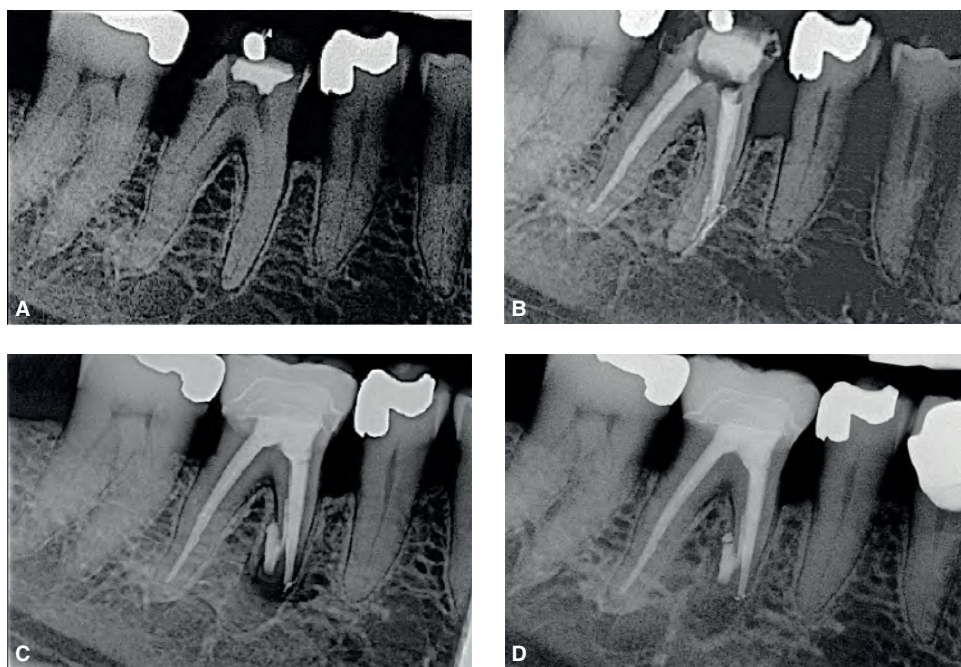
Calcification may complicate root canal treatment. A. Radiograph showing calcific metamorphosis in the coronal third of the root of the mandibular right first molar. The tooth is symptomatic to percussion. B. The clinician was not able to negotiate the mesial canals curvatures and perforated the distal side of the mesial root. The tooth is still symptomatic. C. Apical surgery was attempted to treat the defect. The retrograde filling is not optimum. D. Twelve-month follow-up radiograph showing signs of bony healing. The tooth is no longer symptomatic.
